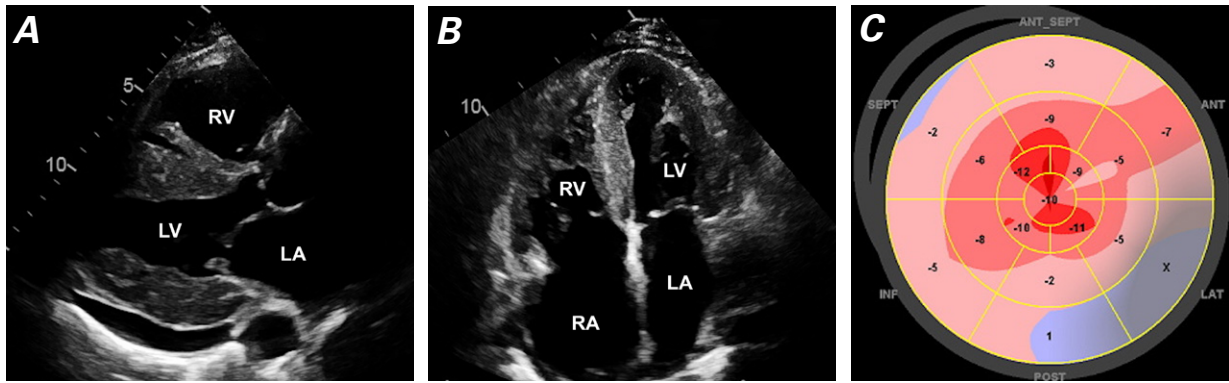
Speckle-tracking echocardiograms obtained in the A) parasternal long-axis and B) apical 4-chamber views show speckling of severely thickened myocardium, normal left ventricular (LV) size, biatrial enlargement, and posterior pericardial effusion. C) A strain imaging map reveals the classic “cherry on top” pattern of apical sparing, which is typical of cardiac amyloidosis.
